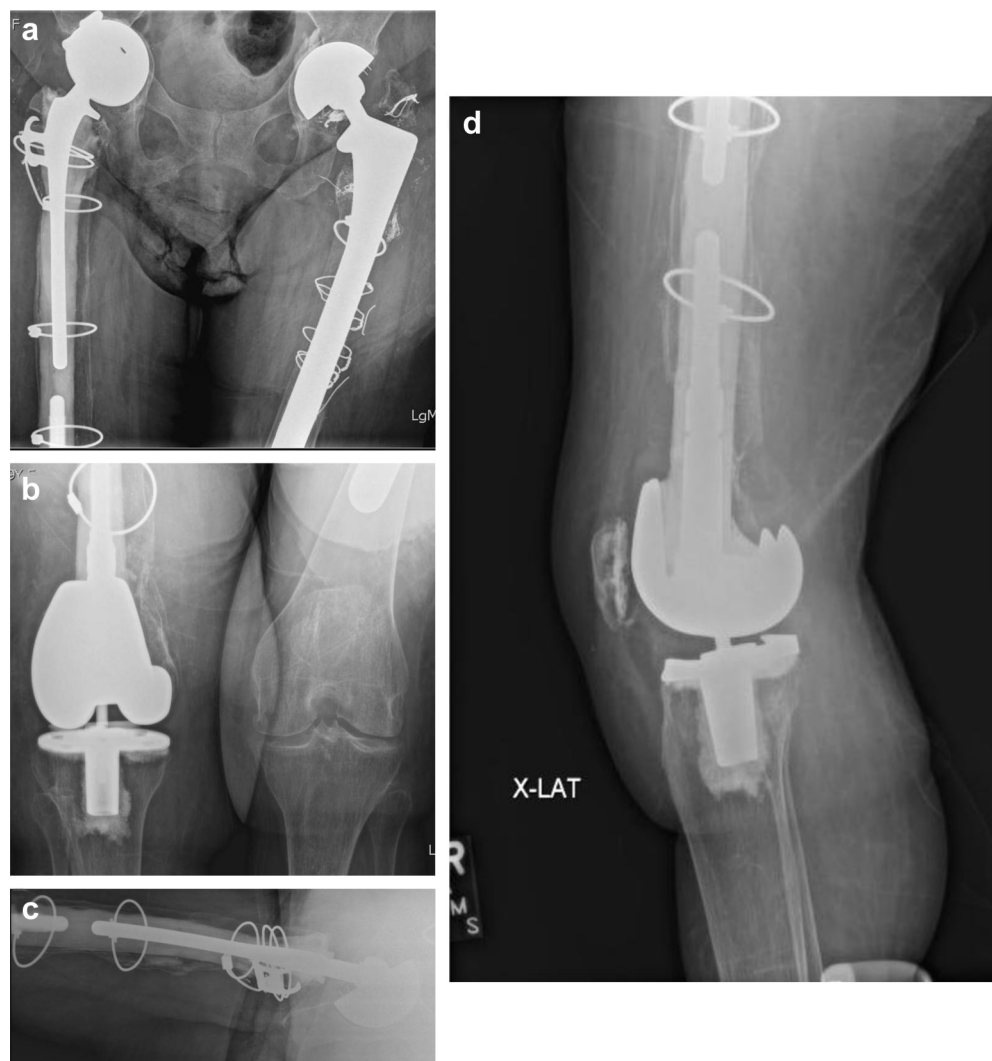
AP pelvis (a) and right knee (b) radiograph 17 years after right total femoral allograft. Lateral right femur (c) and right knee (d) radiograph 17 years after right total femoral allograft.
